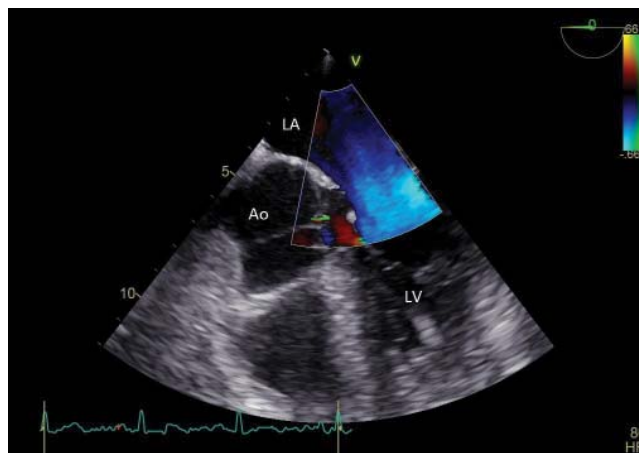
Transesophageal echocardiography midesophageal 5 chamber view-perforation cusp without hemodynamic impact is revealed by colour Doppler examination.
